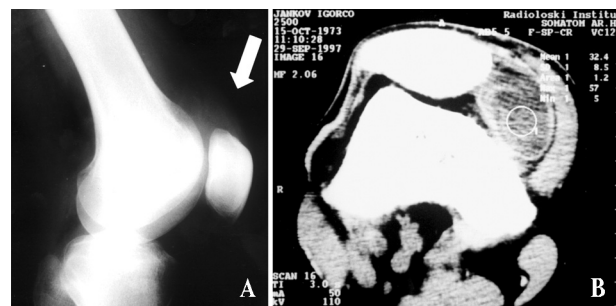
A. Lateral radiograph of the right knee: the arrow points to a parapatellar soft tissue mass B. CT scan of the same knee: parapatellar, intracapsular soft tissue mass which has displaced the patella
